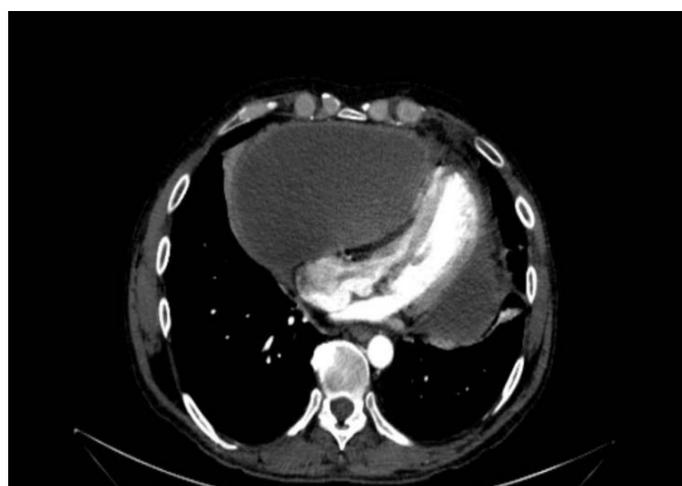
Multidetector CT scan data of patient P., 42 years old, dated August 5th, 2020 (description in the text).
